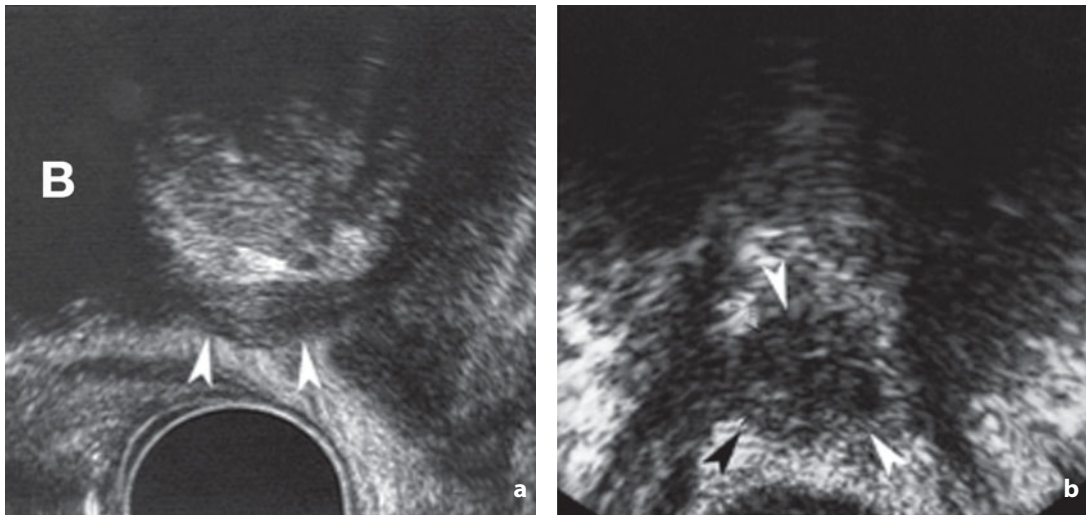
Ultrasonography. Normal postoperative anatomy following radical prostatectomy. a The *arrowheads* in the longitudinal scan indicate the urethra. b The *arrowheads* in the axial scan indicate the symmetrical vesicourethral anastomosis. B, urinary bladder
